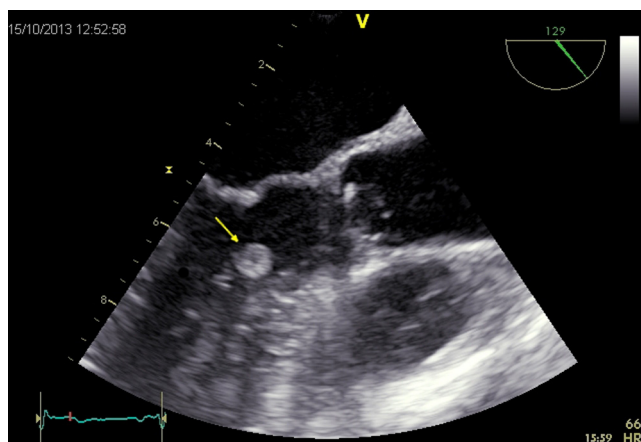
A transesophageal echocardiographic image demonstrating the presence of a pathological mass in the left ventricle (arrow) projecting to the region below the outflow tract (left ventricular longitudinal axis projection).
